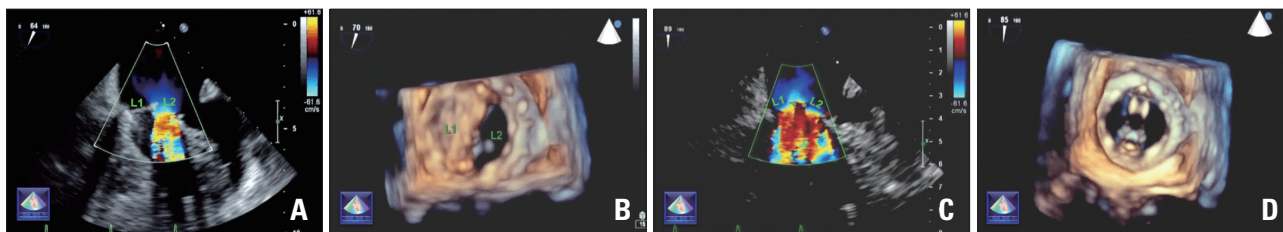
Two dimensional transesophageal echocardiogram (2D TEE) showing one leaflet (L1) blocked, while the second leaflet (L2) is opening with accelerated color flow velocity (A). Real time three dimensional transesophageal echocardiogram (RT3DTEE) view from left atrium revealing one leaflet (L1) blocked, while the second leaflet (L2) is opening (B). 2D TEE after successful treatment leaflets excursion are normal with normal color flow velocity (C) and RT3DTEE (D).
